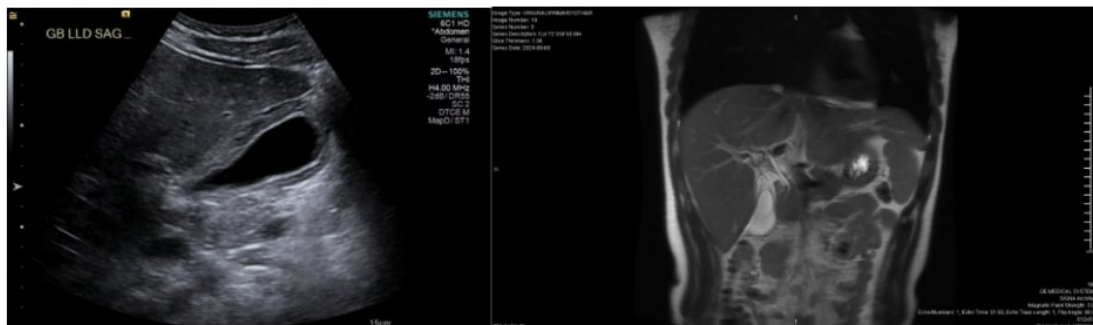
Ultrasound (left) demonstrating gallbladder wall thickening with associated pericholecystic fluid. No evidence of cholelithiasis or sludge. MRCP (right) reveals no evidence of common bile duct dilatation.
